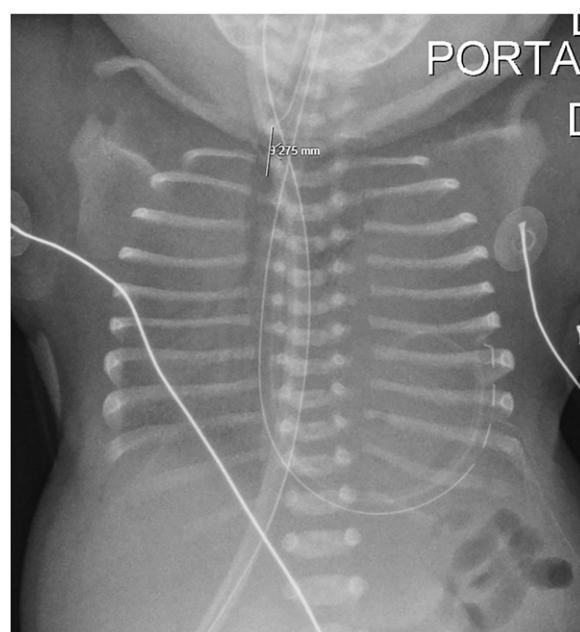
Chest radiograph at approximately 30 minutes of age. Endotracheal tube is in the cervical trachea (subsequently advanced 1 cm). Nasogastric/orogastric tube with tip and side-port projecting over the left lower thorax. There is complete opacification of the thorax with air bronchograms and the cardiomeastinal silhouette is completely obscured by the opacified lungs. Subcutaneous edema is noted as well as 11 ribs bilaterally.
